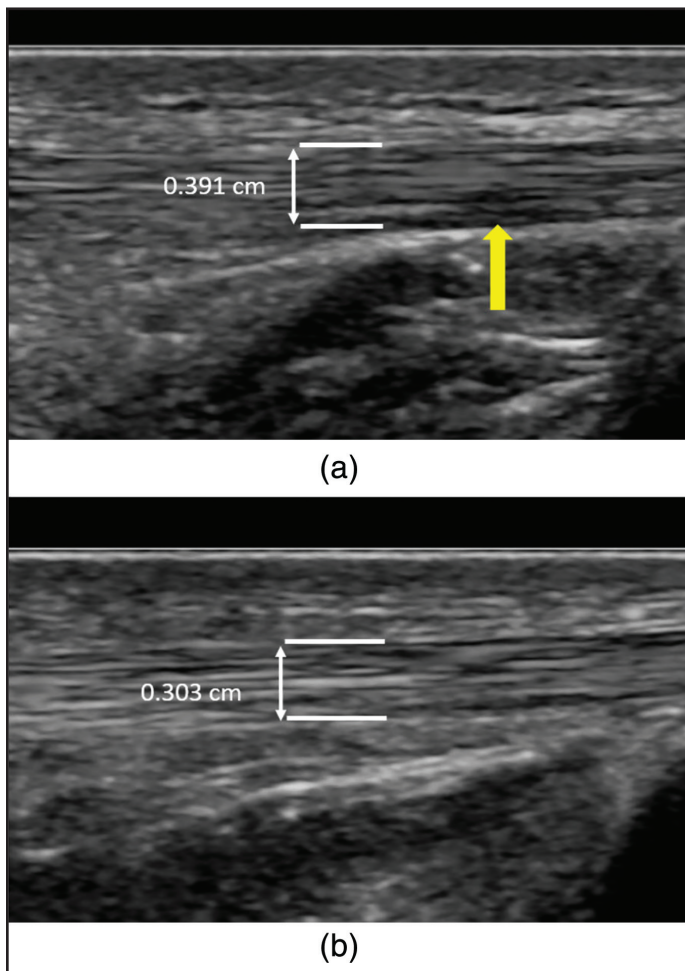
(a) Sonographic Image of Athlete 1's Left Patellar Tendon (Baseline). Arrow pointing to hypoechoic region. Tendon thickness 0.391 cm. (b) Sonographic Image of Athlete 1's Right Patellar Tendon (Baseline). Tendon thickness 0.303 cm.
